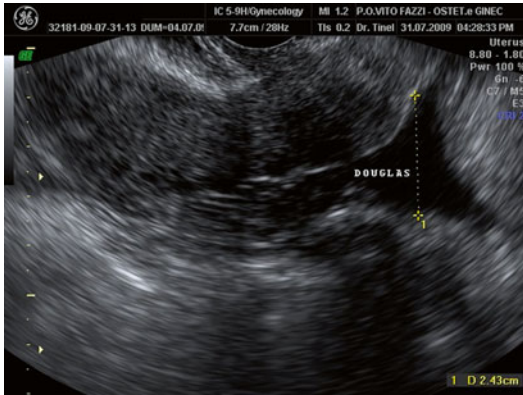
An ultrasonographic transvaginal scan showing an anechoic free fluid in the pouch of Douglas generally detected in not only intra-uterine but also ectopic gestations
